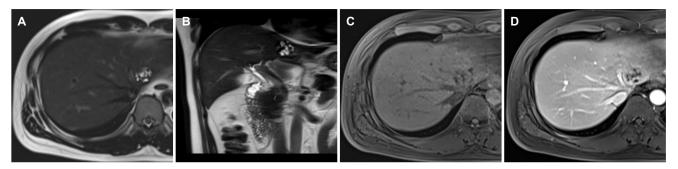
38-year-old man with biliary adenofibroma (case 2). (A) Axial and (B) coronal T2-weighted images showed a multilobulated and multiseptated cystic tumor. (C) Axial unenhanced T1-weighted image showed a tumor with low signal intensity. (D) Axial portal venous phase T1-weighted image showed septal and wall enhancement.
